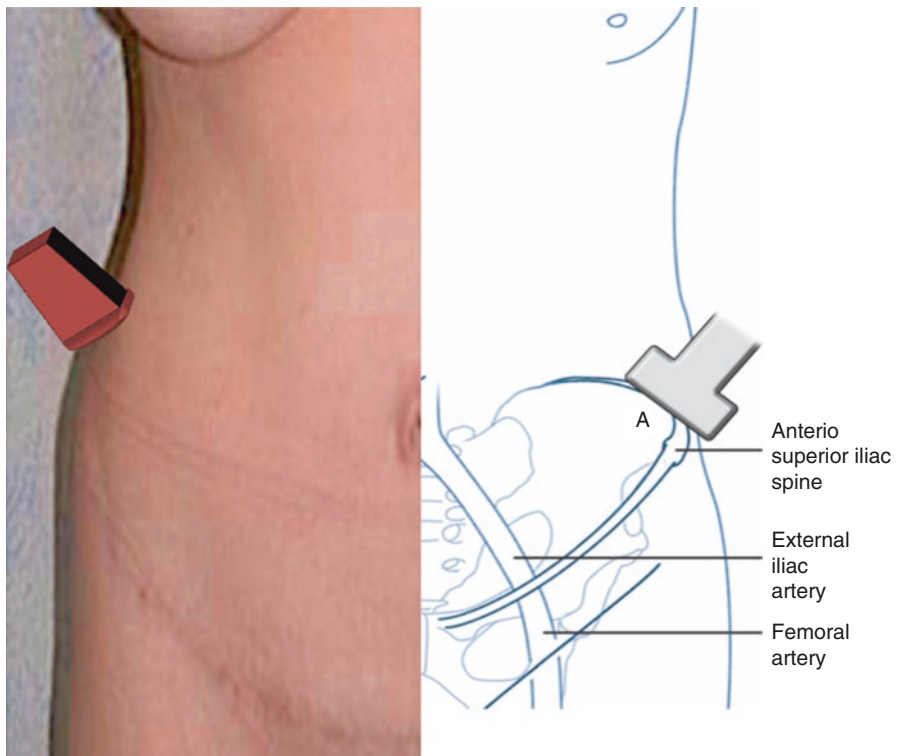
The ultrasound probe position. (Reprinted with permission from Philip Peng Educational Series)
